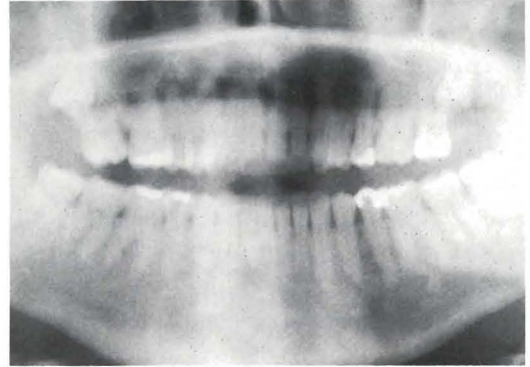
Orthopantomogram of the same patient after five years without any active treatment. The premolars have erupted normally and the alveolar process has recovered its height.
